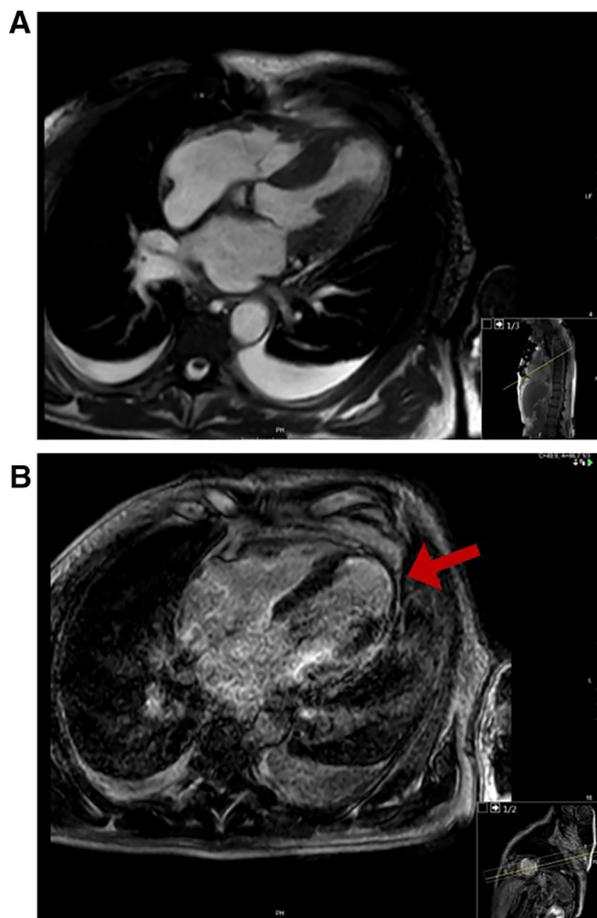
Cardiac MRI (A) after gadolinium administration (B). MRI images show a thinned and akinetic apex with late subendocardial gadolinium enhancement > 50% of thickness with an aneurysmal dilatation of the apex of the left ventricle (LV) in systole, suggestive of necrosis (Red arrow).
